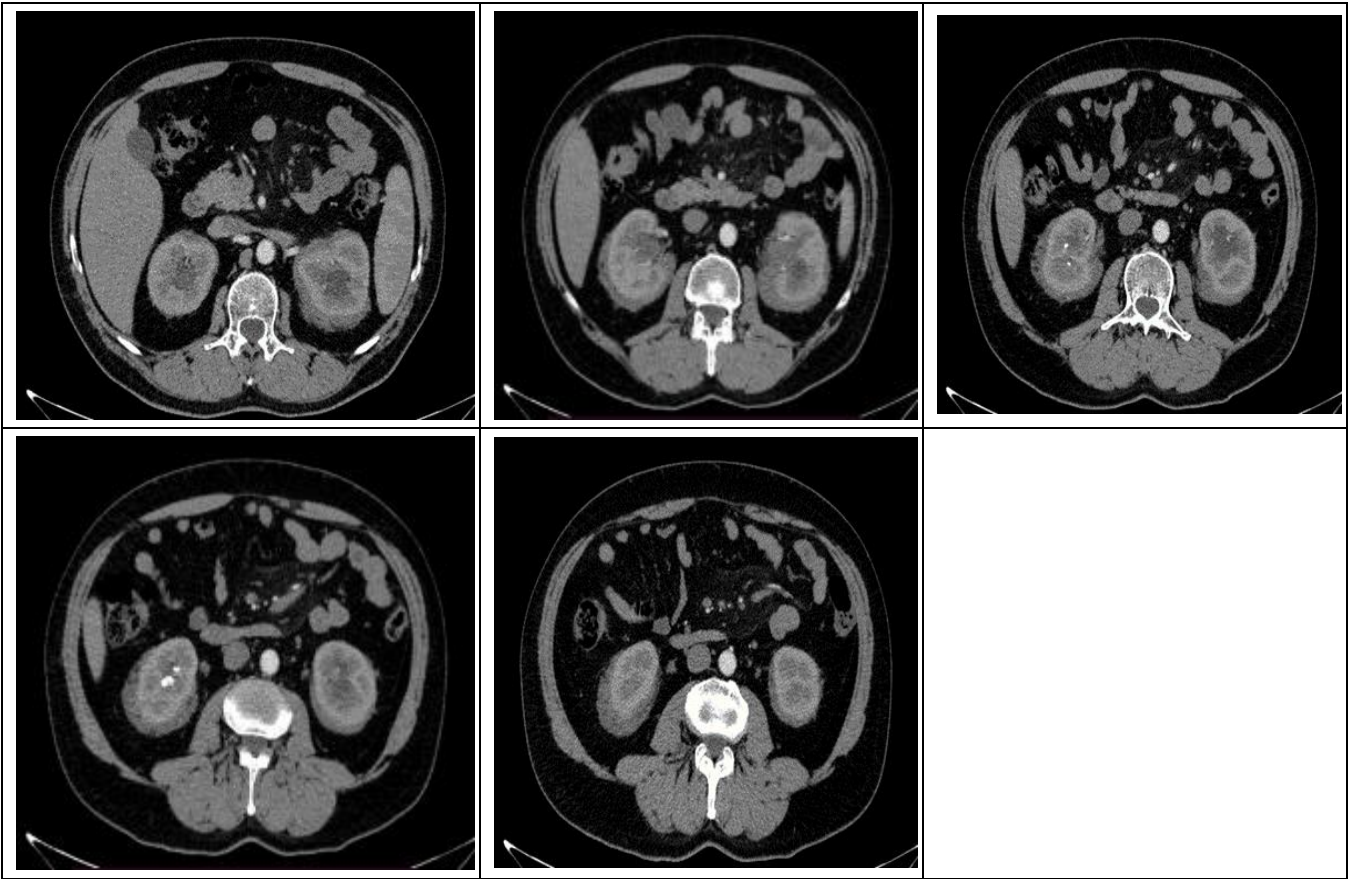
Axial CT scan images showed bilateral almost symmetrical perirenal enhancing soft tissue thickening extending to the renal pelvis and infiltrating the pelvicalyceal systems, associated with moderate hydronephrosis, giving the appearance of "hairy kidneys."
